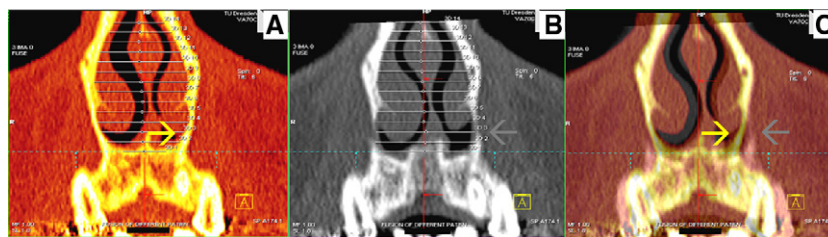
Three-dimensional depiction of the morphologic changes in a 24-year-old patient near the apertura piriformis at T1 and T2 of a bone-borne RME with the DD: A, CT scan at T1 (yellow arrow); B, CT scan at T2 (arrow shows growth); C, superimposition of CT scans from T1 and T2 (yellow and grey arrows show CT-Osteo-3D-Fusion).
